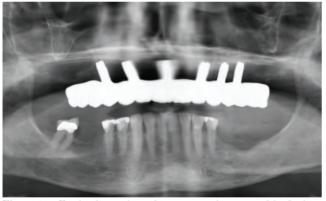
Final radiograph verifying proper placement of the final restoration
